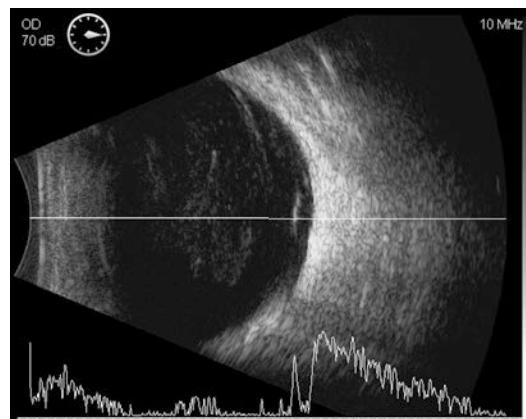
Initial B-scan ultrasonography indicated vitreous opacity
